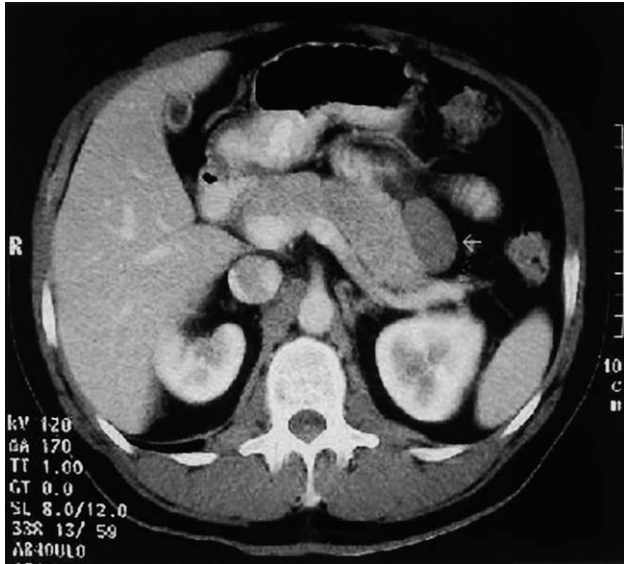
Helical CT scan showing a 4 × 2.5 cm mass with a soft tissue component in the tail of the pancreas (arrow) without enhancement after intravenous contrast injection.
